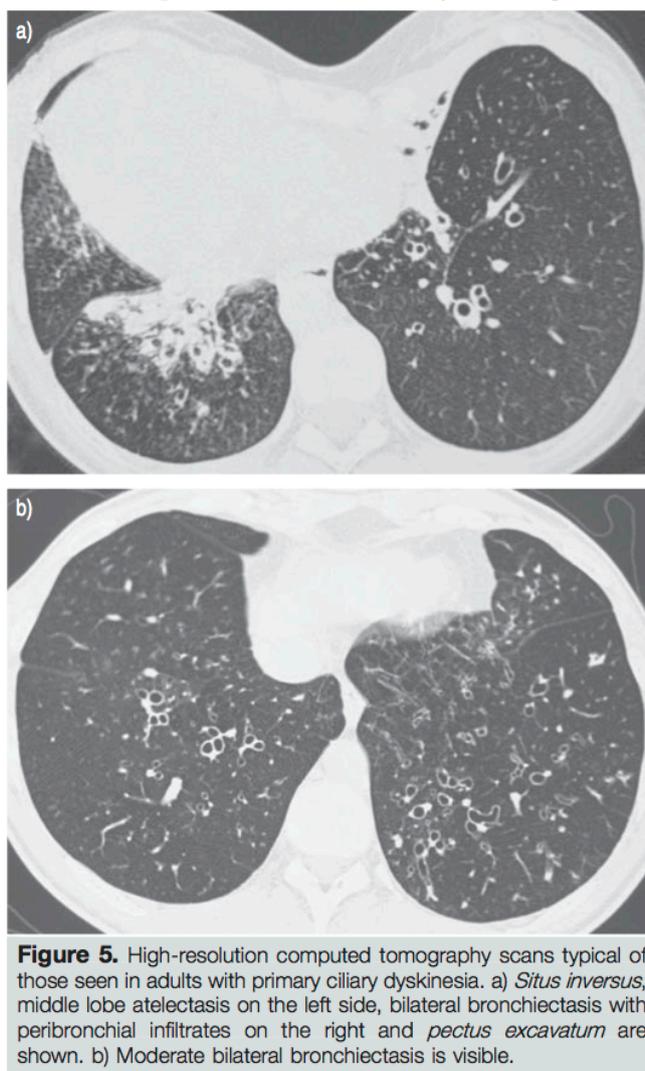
High-resolution computed tomography scans typical of those seen in adults with primary ciliary dyskinesia. a) *Situs inversus*, middle lobe atelectasis on the left side, bilateral bronchiectasis with peribronchial infiltrates on the right and *pectus excavatum* are shown. b) Moderate bilateral bronchiectasis is visible.
